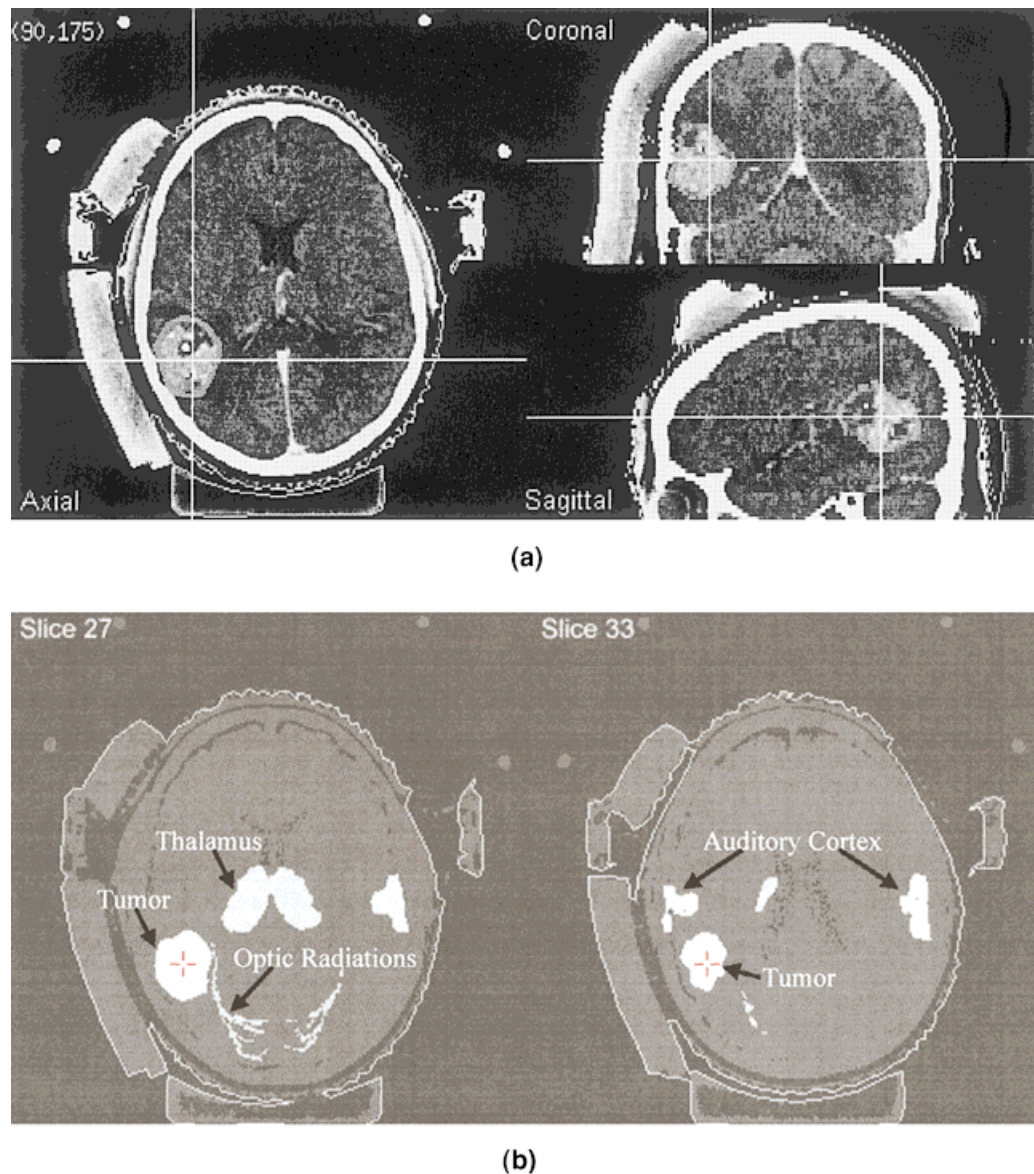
A clinical case shown in triplanar views. (a) original CT image; (b) segmented image with critical structures labeled. The critical structures were obtained by elastically adapting a digital anatomical atlas.^{30,31}
